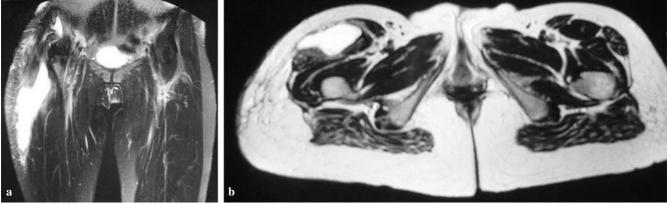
T2-weighted coronal (a) and axial (b) magnetic resonance images indicating subcutaneous fluid collection
